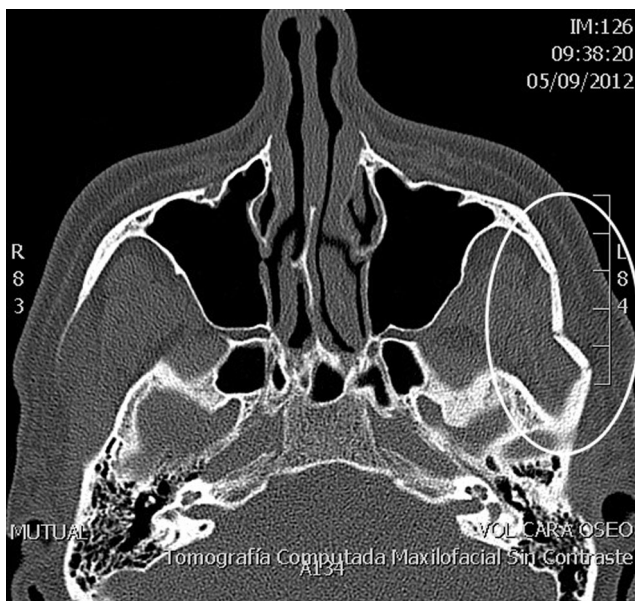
Pre-operative craniofacial non-contrast CT. Axial cross-section. “M-shaped” isolated zygomatic arch fracture of the left side
